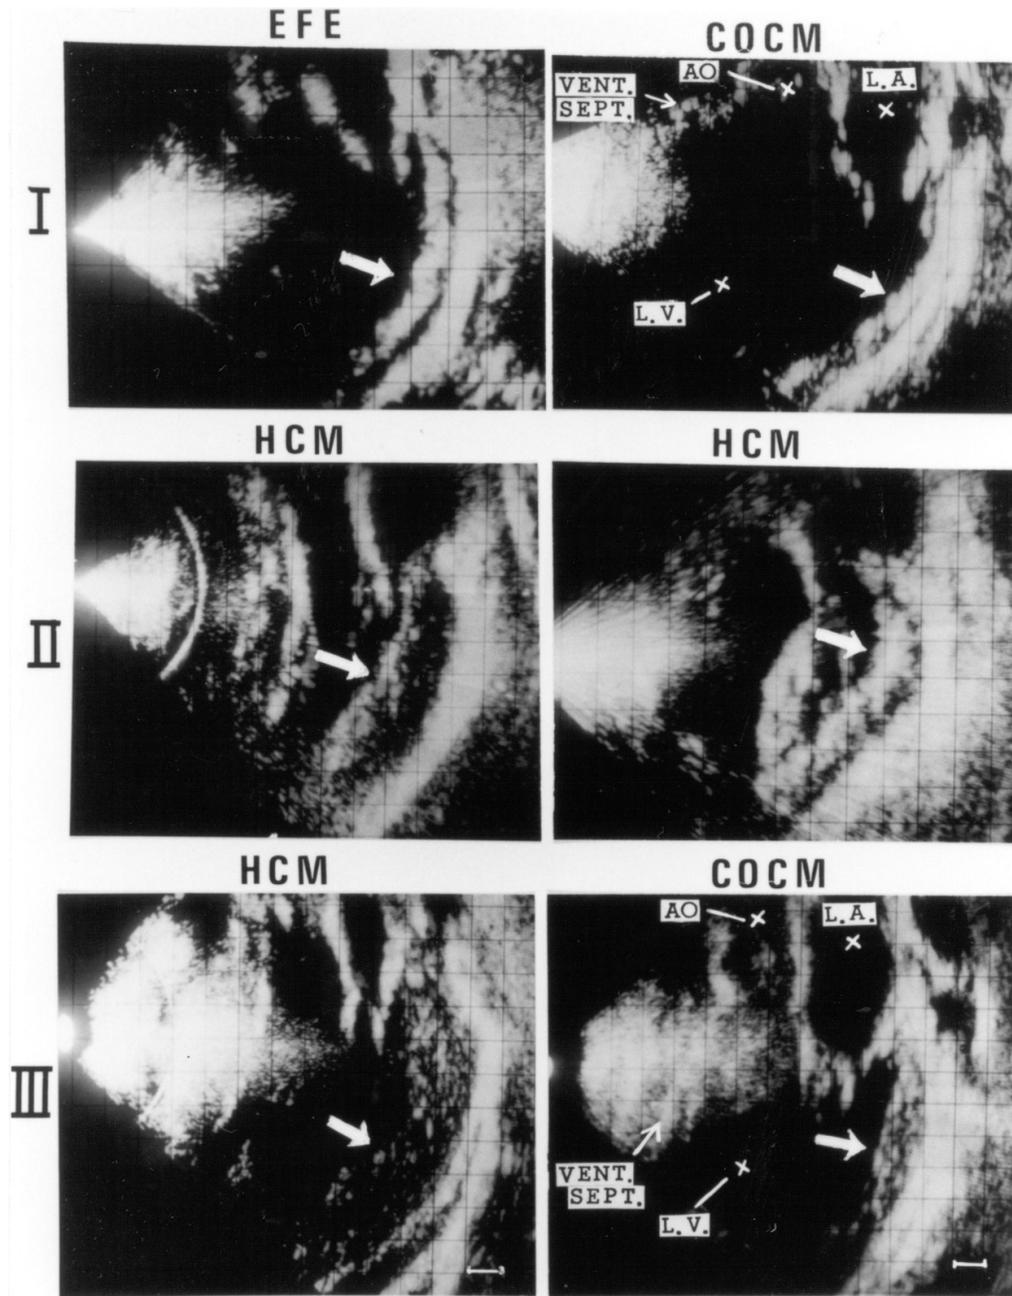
Three major types of abnormal echo patterns observed with 2-dimensional echocardiograms of the left ventricular wall in cases with the myocardial damage. EFE = Endocardial fibroelastosis, COCM = dilated cardiomyopathy, and HCM = hypertrophic cardiomyopathy. White arrows show the abnormal echo.
